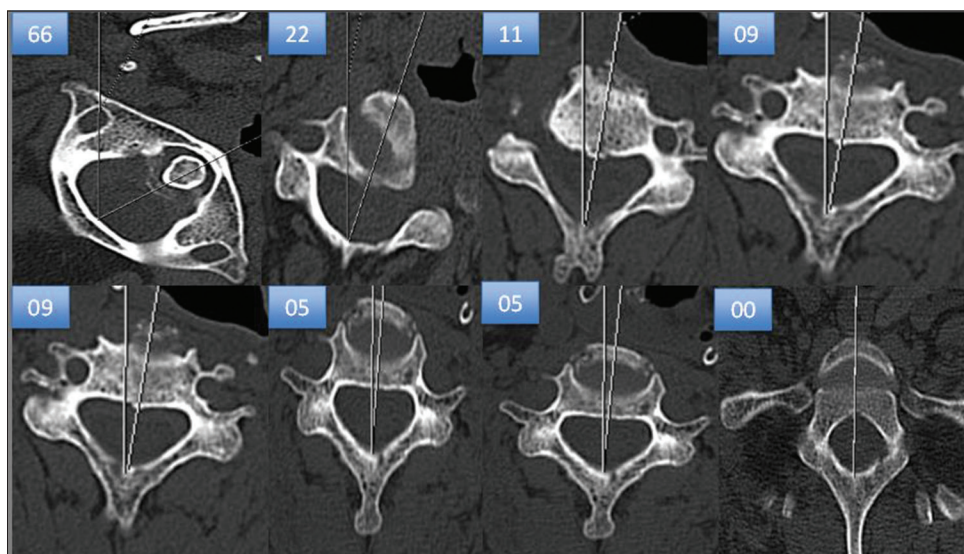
Preoperative axial computed tomography sections showing axial range of motion to the left
